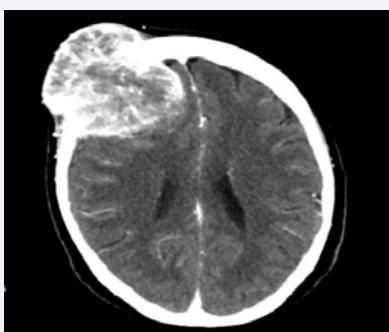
Axial brain CT.
